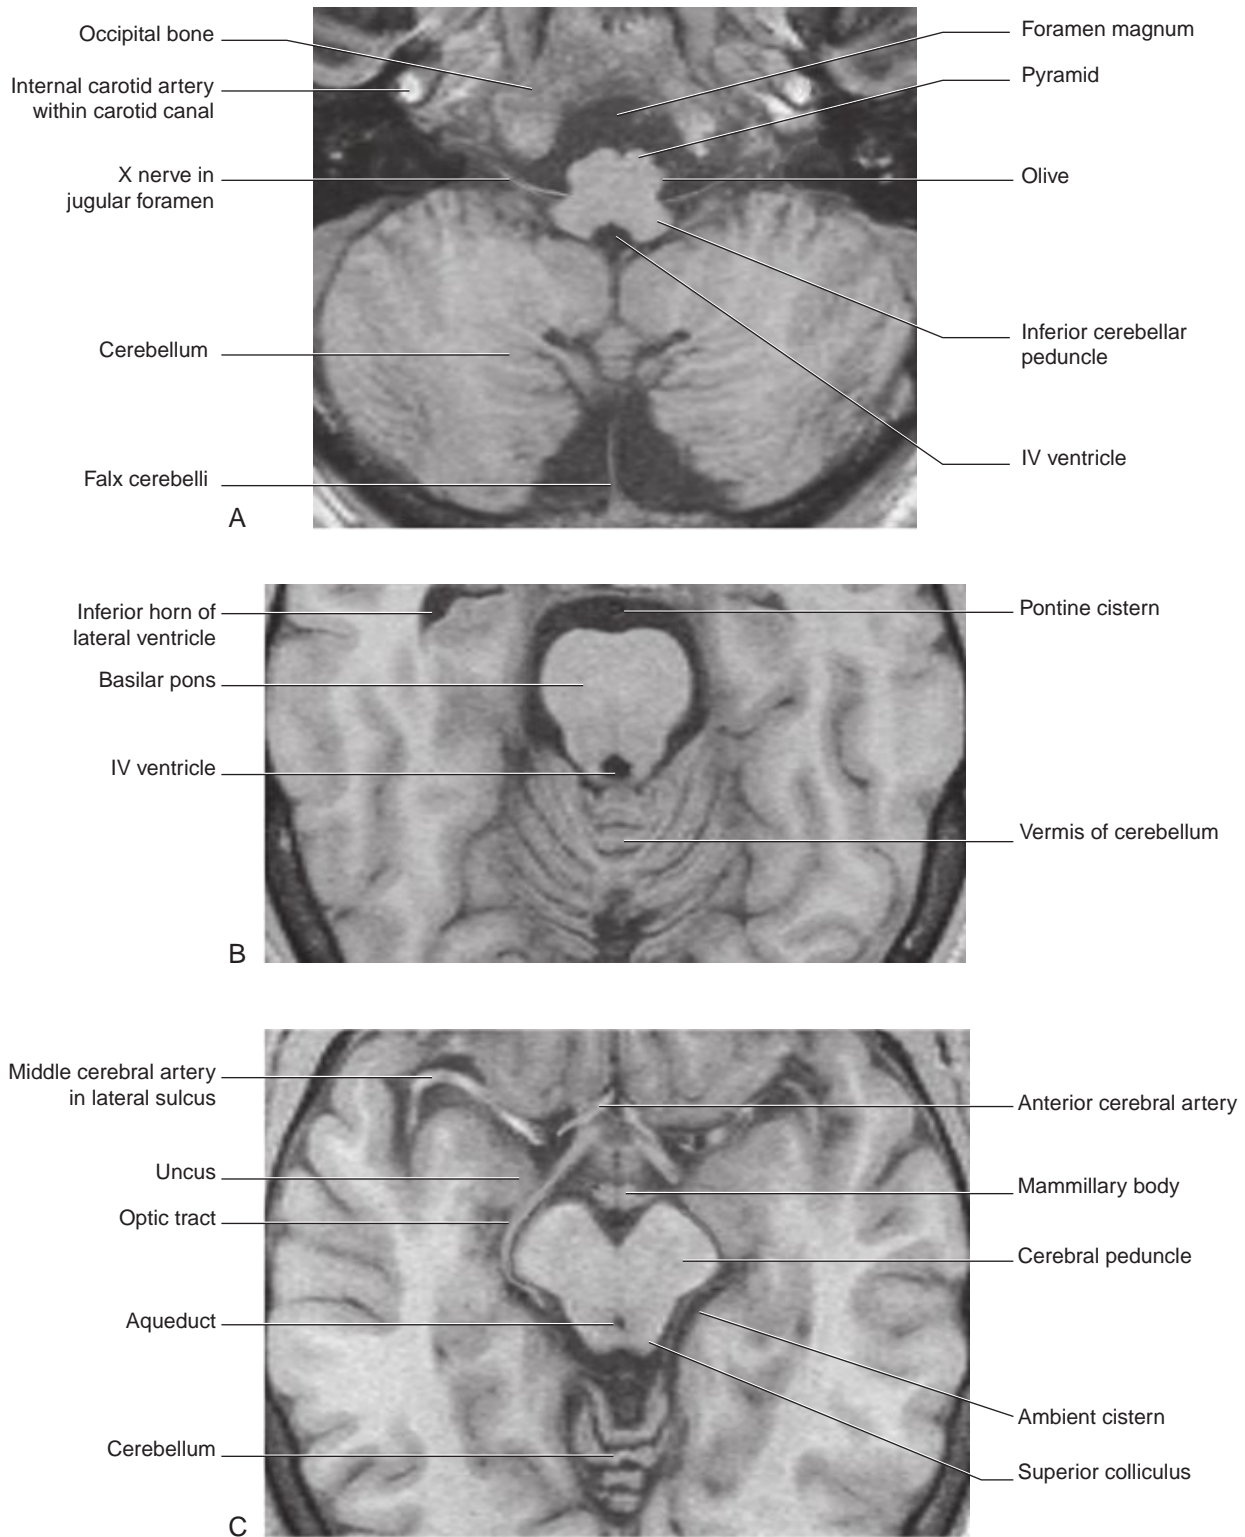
Magnetic resonance images of (A) medulla oblongata, (B) pons, and (C) midbrain in the standard radiologic orientation. (From a series kindly provided by Professor J. Paul Finn, Director, Magnetic Resonance Research, Department of Radiology, David Geffen School of Medicine at UCLA, California.)
